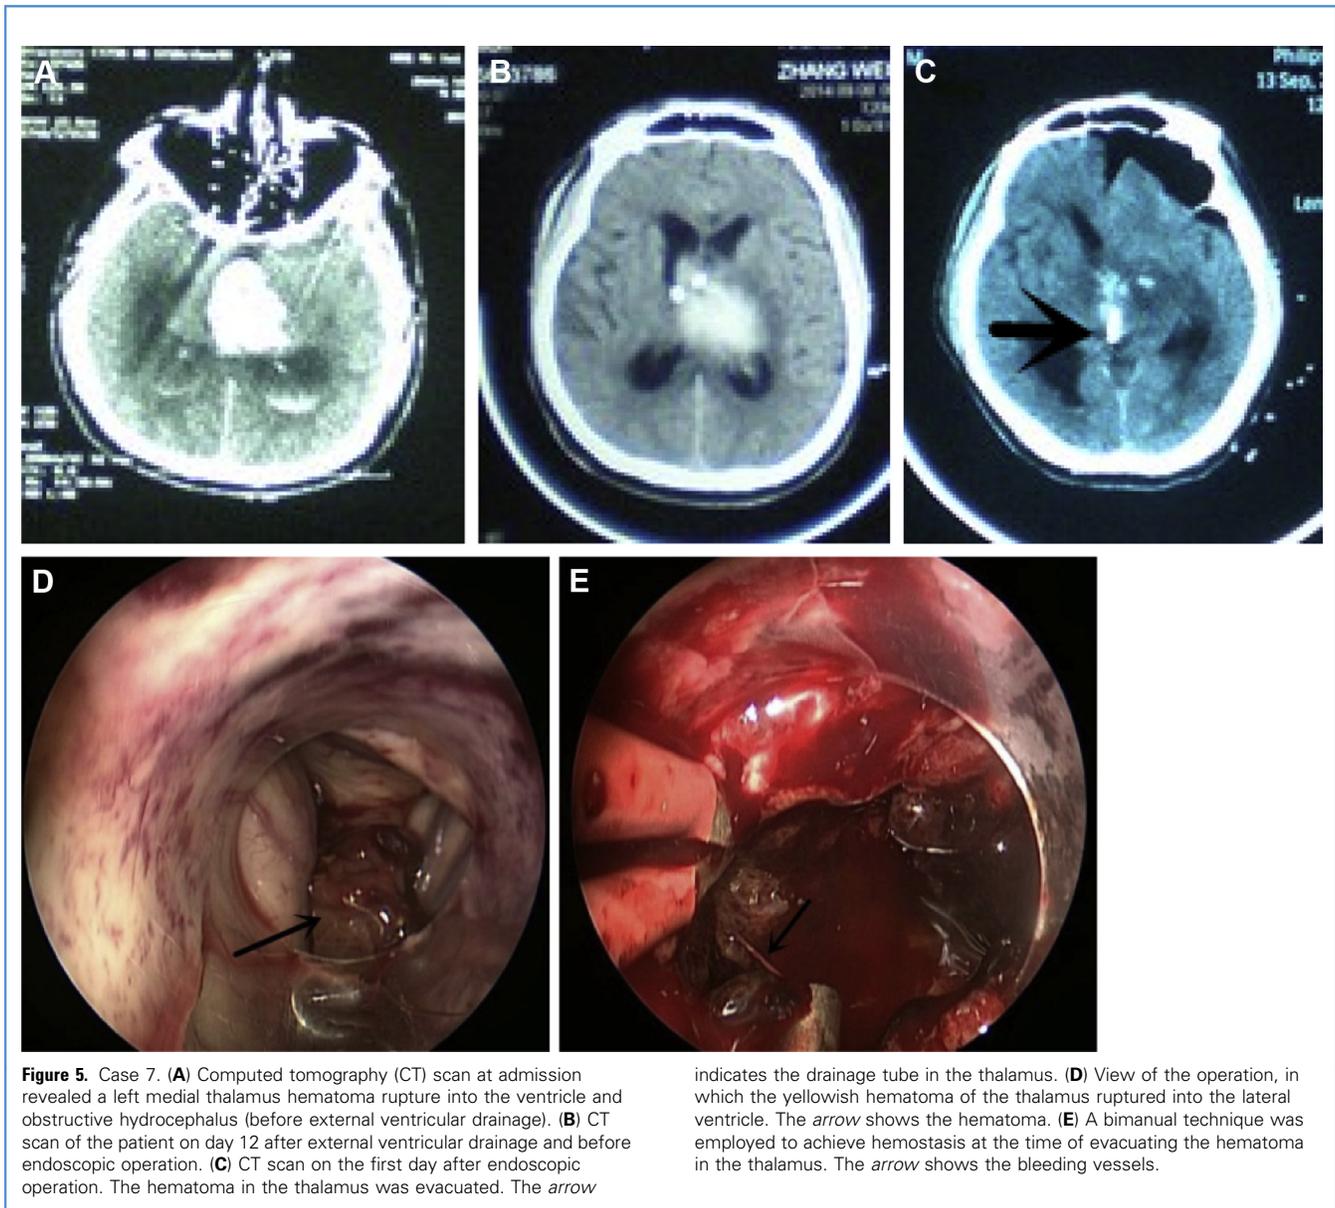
Case 7. (A) Computed tomography (CT) scan at admission revealed a left medial thalamus hematoma rupture into the ventricle and obstructive hydrocephalus (before external ventricular drainage). (B) CT scan of the patient on day 12 after external ventricular drainage and before endoscopic operation. (C) CT scan on the first day after endoscopic operation. The hematoma in the thalamus was evacuated. The arrow
